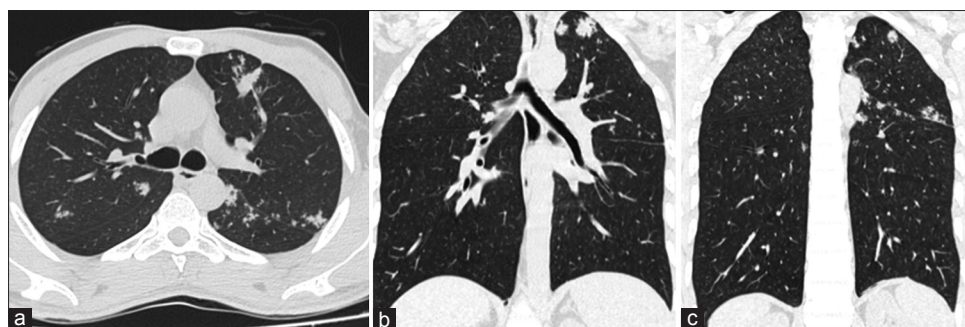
Case of tuberculosis - human immunodeficiency virus (a) Axial, (b and c) coronal HRCT images reveal multiple nodules some are conforming to tree-in-bud nodules
